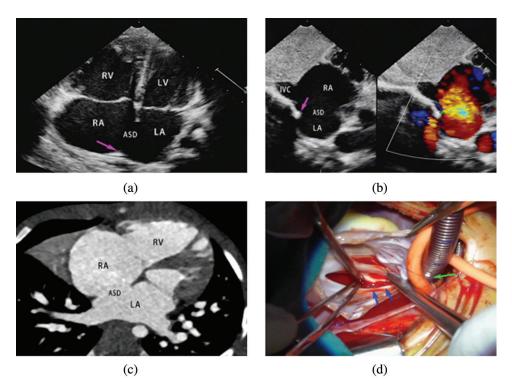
Large secundum ASD adjacent to inferior vena cava. (a) Large secundum ASD with a residual posterior atrial septal rim (arrow) were shown in apical four-chamber view. (b) Subcostal sagittal view. ASD was adjacent to inferior vena cava with a posterior and inferior atrial septal rim (arrow) were shown. (c) CT image. Large ASD and pulmonary veins returned normally. (d) Surgical findings demonstrated that an oval shaped large ASD was adjacent to inferior vena cava. Green arrow indicates inferior vena cava cannula. Blue arrow indicates posterior atrial rim of ASD (ASD, atrial septal defect)
